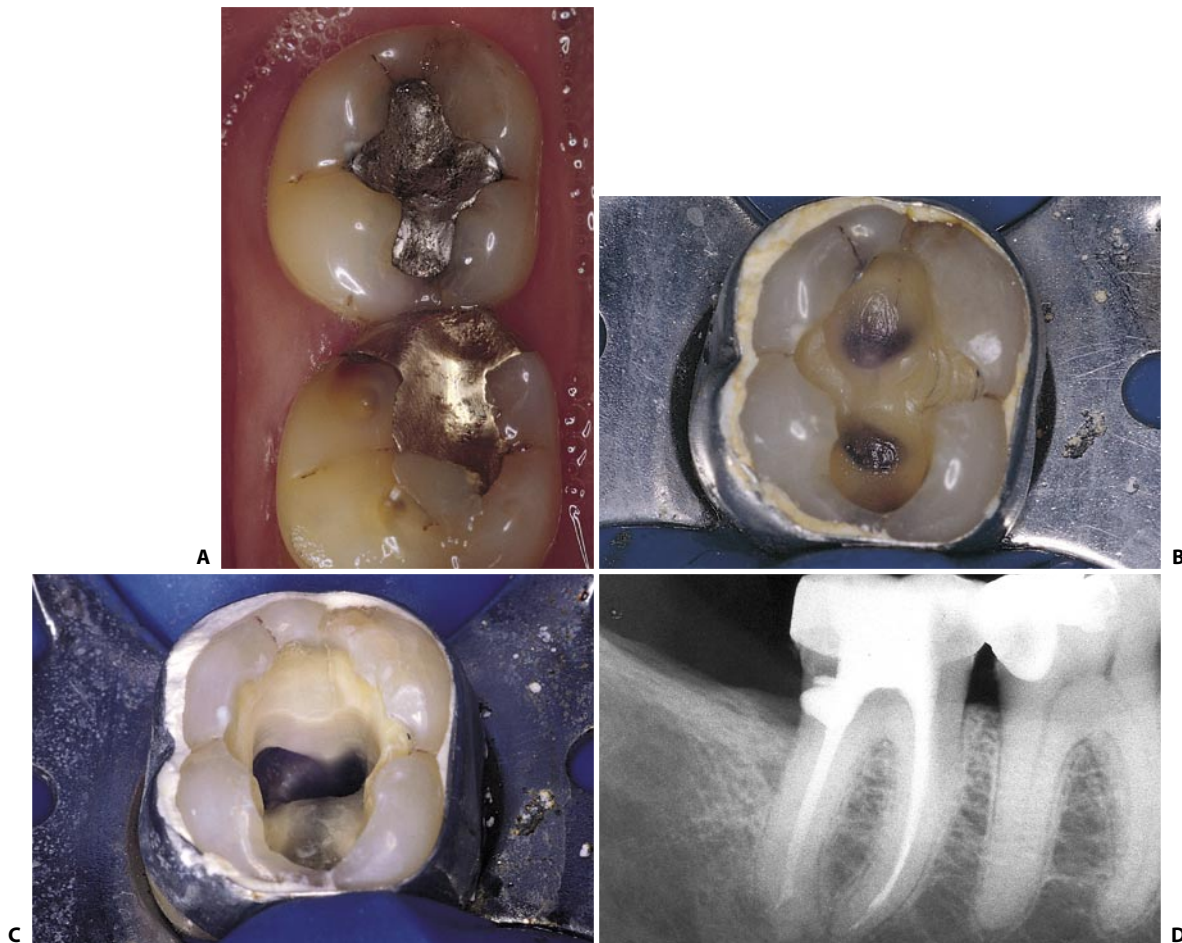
A. The lower right second molar presents all the symptoms of a dentinal crack. B. The tooth has been pretreated with an orthodontic band, and the old occlusal amalgam was removed. Note the presence of a mesiodistal crack. C. Once the access cavity has been created, the crack is visible along the entire distal wall of the pulp chamber. D. Postoperative radiograph.
